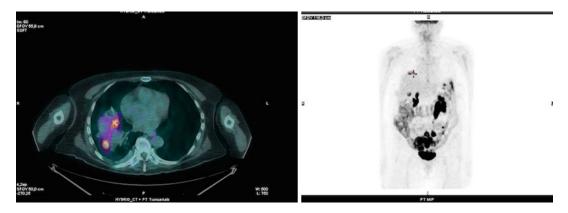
A 49-year-old female submitted to perform an ¹⁸FDG PET/CT for cervical cancer staging. ¹⁸FDG PET/CT depicts a distant metastasis on liver capsule (markers)
